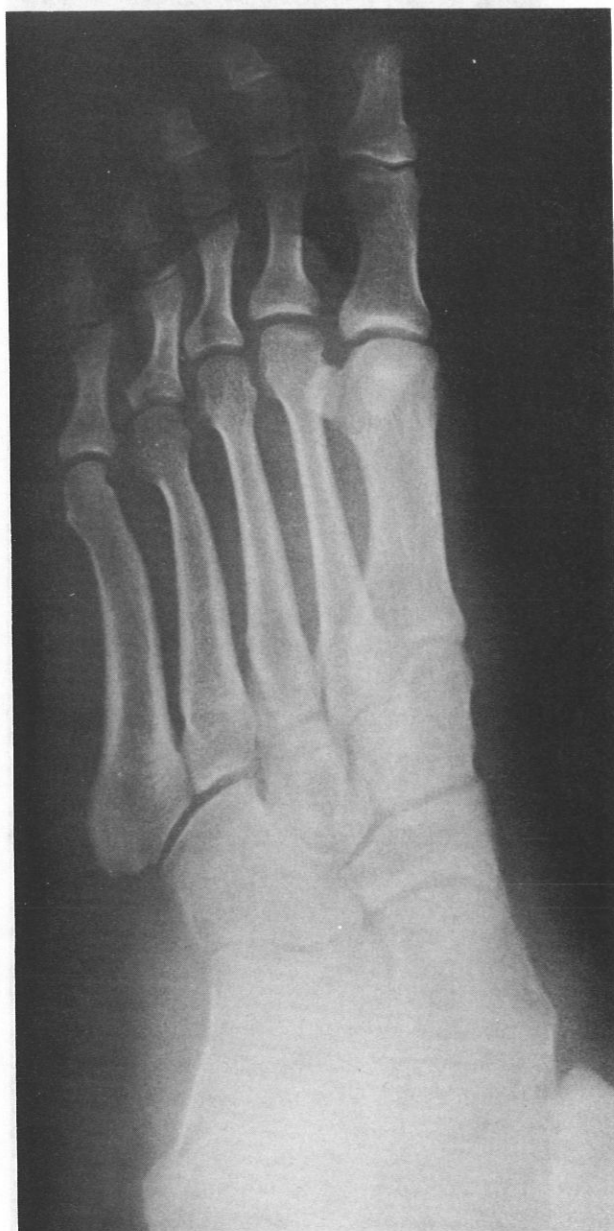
A and B.—Anteroposterior (AP) and oblique X-ray views show no abnormality.
